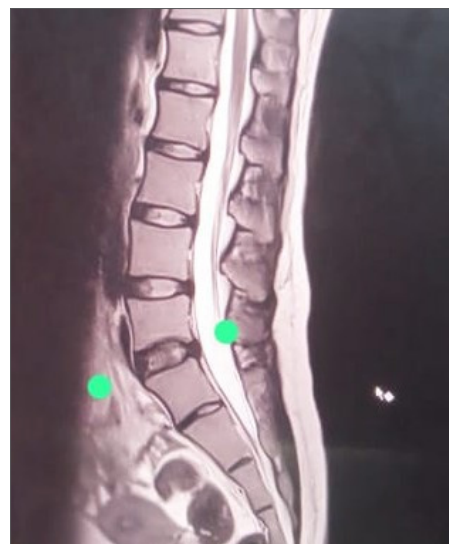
Sagittal T2-weighted MRI of the lumbosacral spine demonstrating partial sacralisation of L5 with pseudo-articulation of the transverse process and rudimentary L5–S1 disc.
